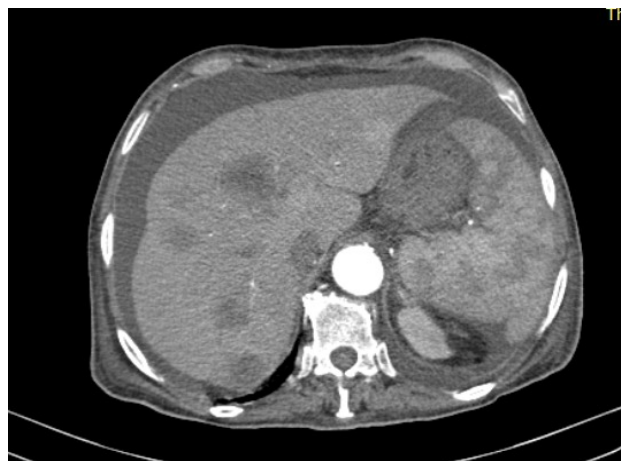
Computed tomography scan data revealed a 12 cm-diameter mass in the antro-pyloric region, with secondary hepatic locations.
